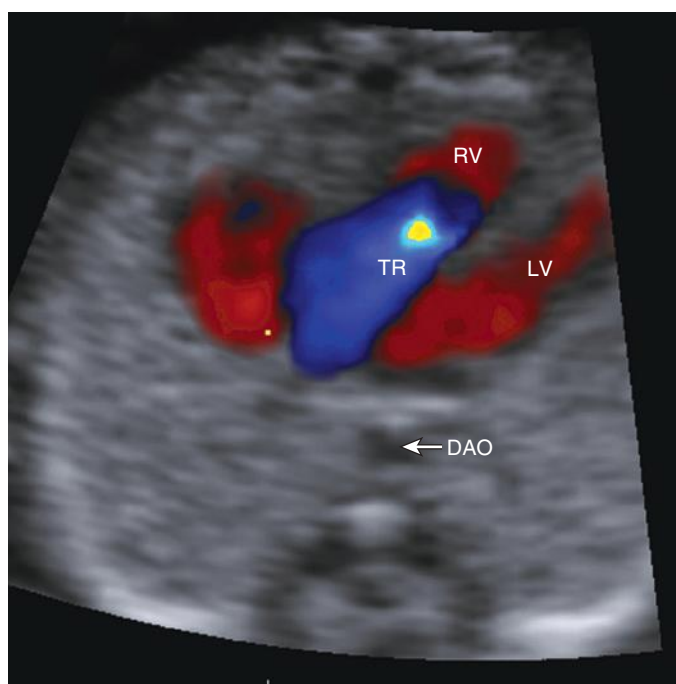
Color Doppler imaging demonstrates severe tricuspid regurgitation in a fetus with Ebstein anomaly at 13 $\frac{4}{7}$ weeks of gestation. DAO, descending aorta; LV, left ventricle; RV, right ventricle; TR, tricuspid regurgitation.
